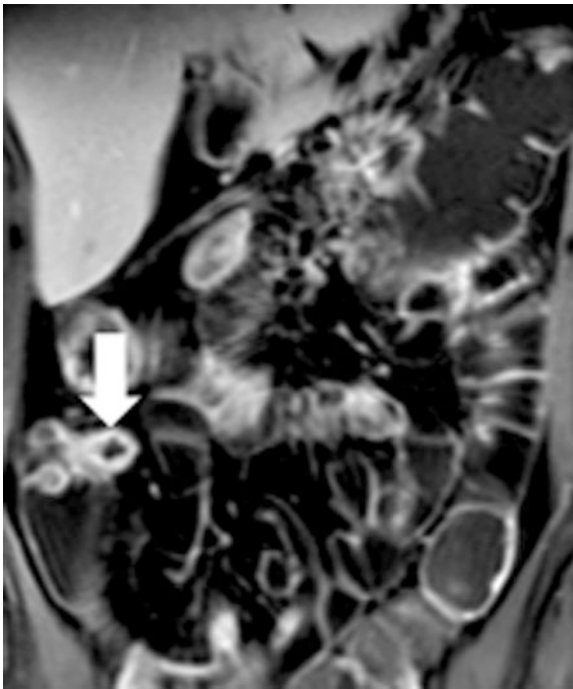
Dark lumen MRC: Coronal T1-weighted SPGR post IV shows acutely inflamed distal ileum (*arrows*), in a patient with active Crohn's disease (Courtesy of Andrea Laghi, MD, University of Rome, Latina, Italy)
